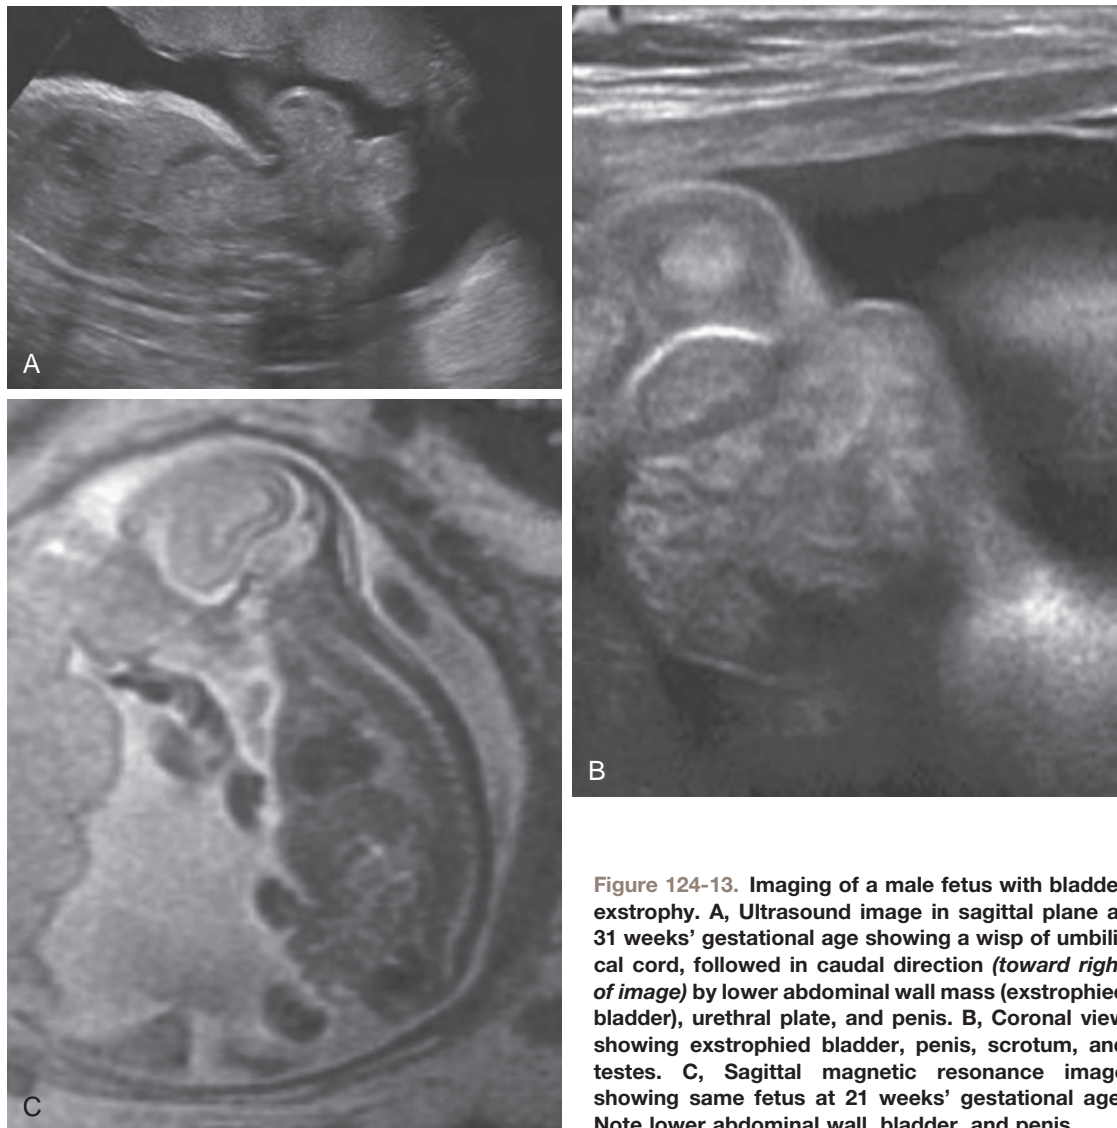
Imaging of a male fetus with bladder exstrophy. A, Ultrasound image in sagittal plane at 31 weeks' gestational age showing a wisp of umbilical cord, followed in caudal direction (*toward right of image*) by lower abdominal wall mass (exstrophied bladder), urethral plate, and penis. B, Coronal view showing exstrophied bladder, penis, scrotum, and testes. C, Sagittal magnetic resonance image showing same fetus at 21 weeks' gestational age. Note lower abdominal wall, bladder, and penis.
